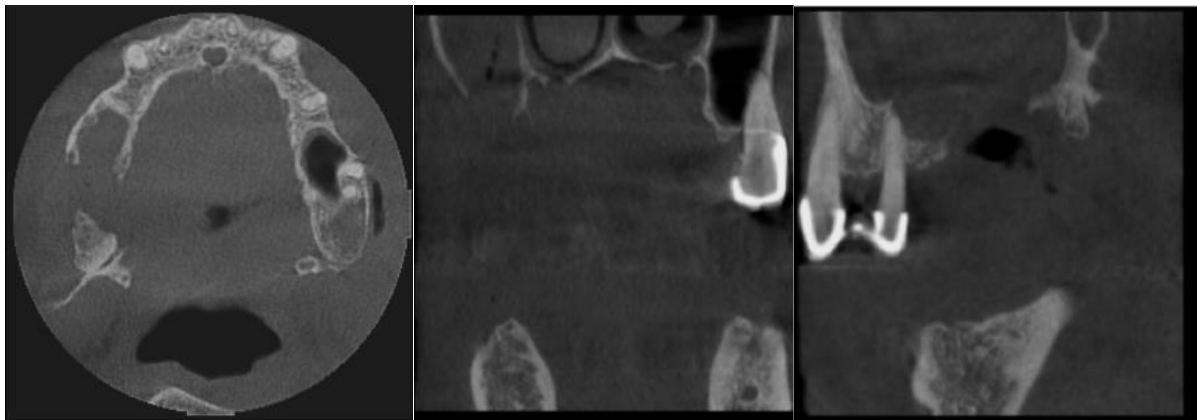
The ragyoopaque image of the right maxillary sinus in CBCT sections.
